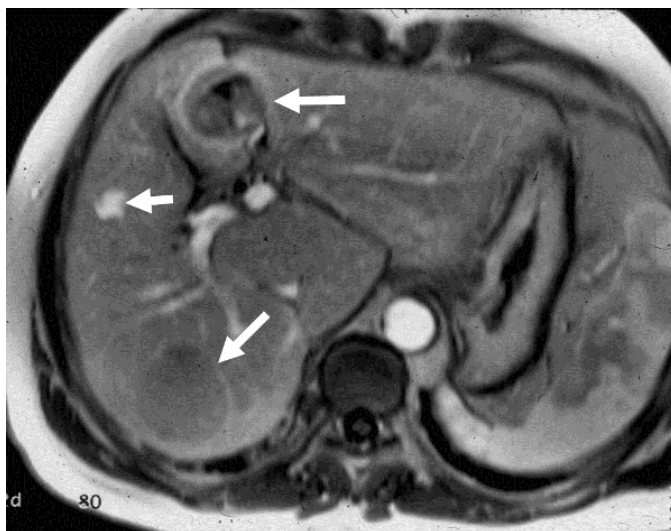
Hepatocellular carcinomas have numerous appearances on MRI. This gadolinium-enhanced T1W GRE image shows three HCCs (arrows), each with slightly different morphology.
